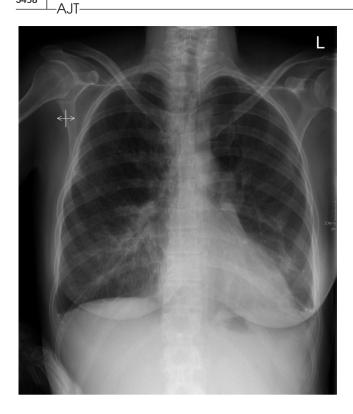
Maternal chest X-ray on postoperative day 3
